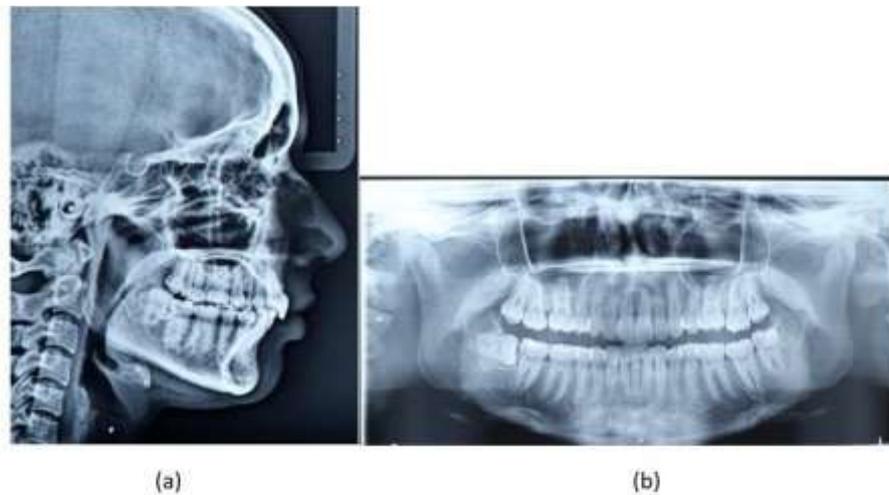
Posttreatment radiographs of the patient (a) lateral cephalogram (b)
